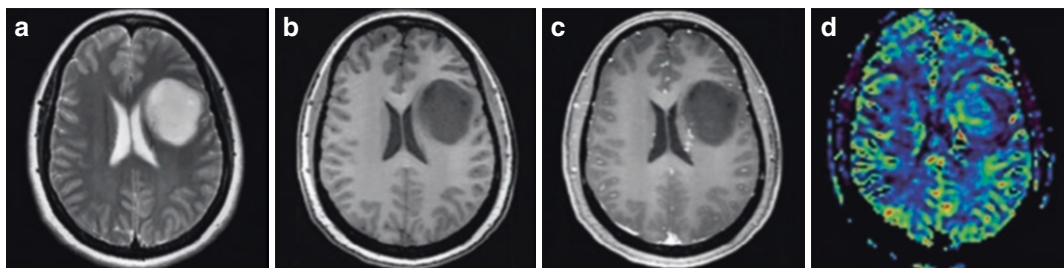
IDH-mutant astrocytoma. A 31-year-old female patient whose MRI shows a circular mass in the left frontoparietal lobe. Transverse T₂WI shows heterogeneous hyperintense signals (a); transverse T₁WI shows homogeneous hypointense signals (b), without no obvious signs of edema around the lesion; contrast-enhanced
